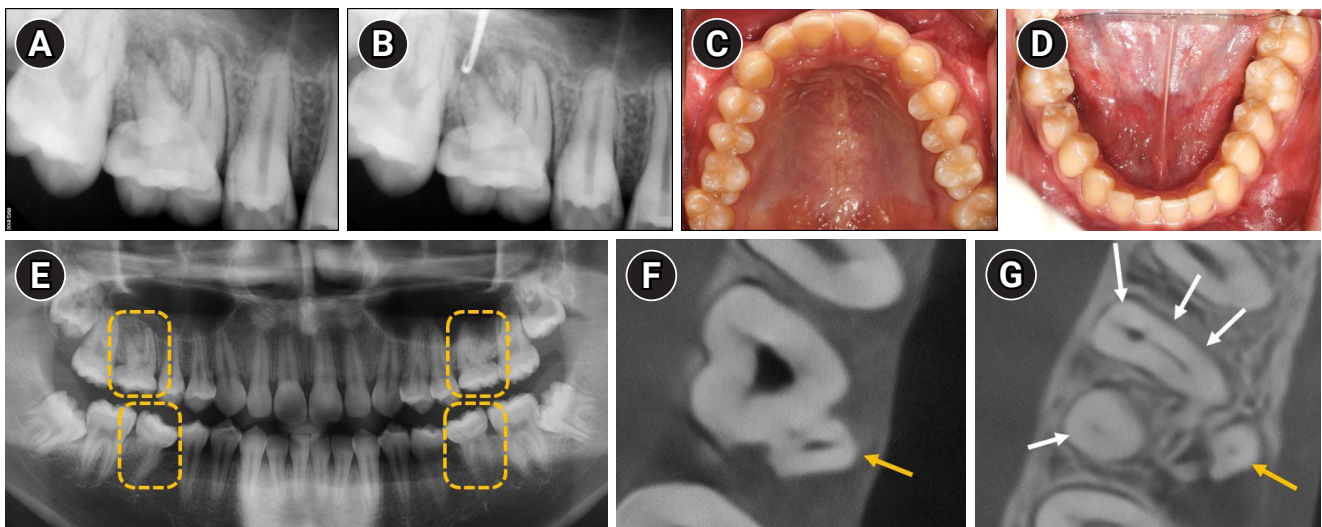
Diagnostic evaluation of maxillary right first molar and overall dentition. (A) Periapical radiograph showing an ill-defined radiolucency associated with tooth #16. (B) Radiograph confirming communication of the sinus tract with the periapical area. (C, D) Intraoral photographs showing normal coronal morphology of all first molars. (E) Panoramic radiograph revealing that all first molars have shortened, tapered roots. Yellow dashed boxes highlight the affected maxillary and mandibular first molars on both sides. (F) Cone-beam computed tomography (CBCT) axial view demonstrating that the palatal canal (yellow arrow) is not in continuity with the pulp chamber. (G) CBCT showing five root canals: three in the mesiobuccal root, and one each in the distobuccal (four white arrows) and palatal roots (yellow arrow).
